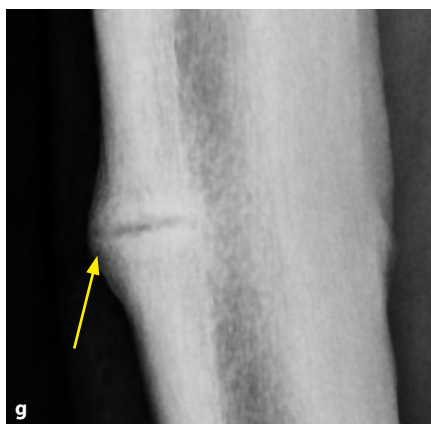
f, g. X-rays of the right tibia at 34.3 years of age show a late repair reaction (remodelling) at 3.9 years after the start of treatment. The images clearly show a transverse light narrow line (arrows) at the apex of the anterolateral cortical curvature. g. detail of losser's zone
